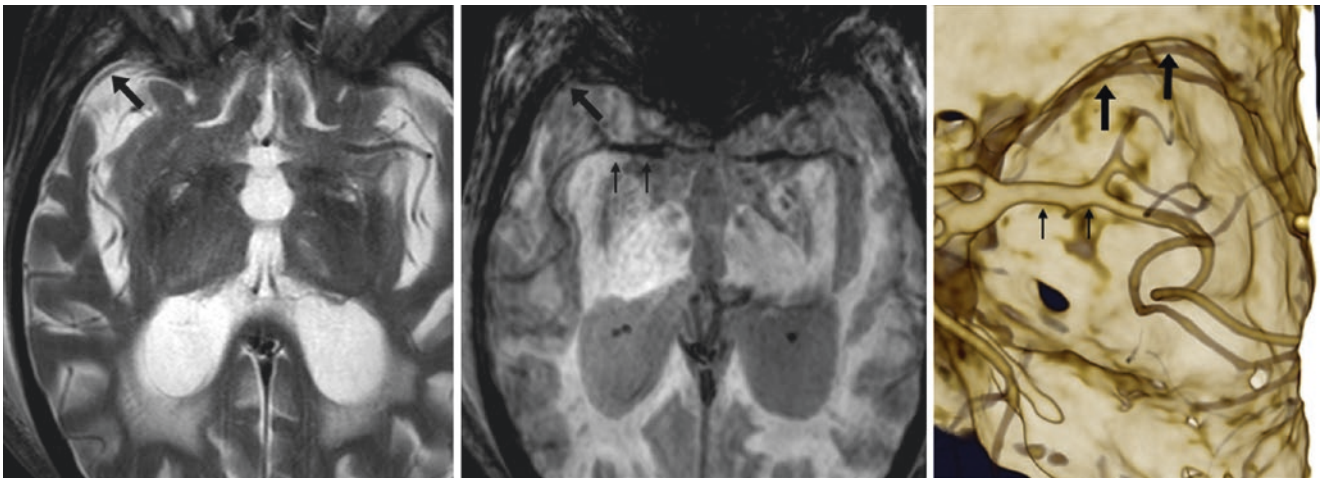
94-year-old with a small right SPS (*large arrows*) depicted by a flow void on an axial T2WI MRI (*left*), an SWI MRI (*middle*), and on a 3D VR CTA superior view (*right*); the two adjacent veins along the inner aspect of the lesser wing of the sphenoid combine to form the SPS. The right MCA (*thin arrows*) is also shown
